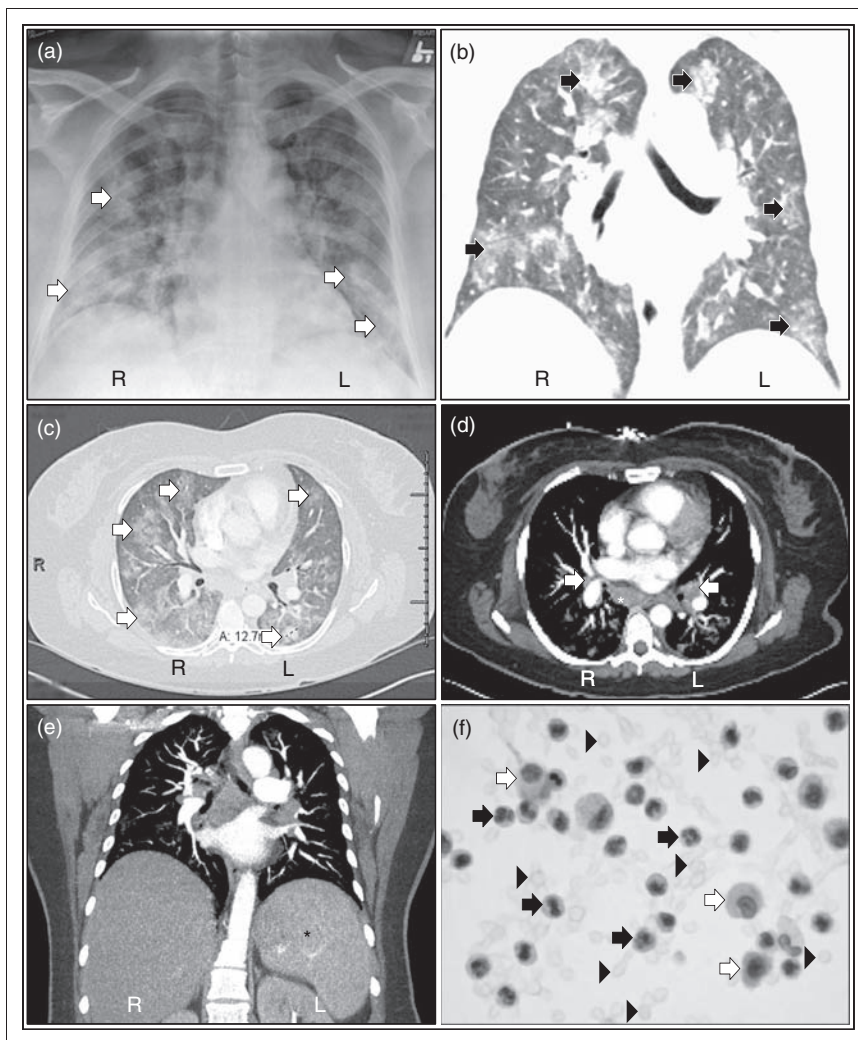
Diffuse alveolar hemorrhage. A chest radiograph demonstrating bilateral patchy airspace opacities (arrows) in the lungs (a). Computed tomographic angiography of the chest and upper abdomen showing bilateral patchy ground-glass opacities (arrows) in the lungs (b, c), enlarged mediastinal (asterisk) and hilar (arrows) lymph nodes (d) as well as enlarged spleen (asterisk) (e). Bronchoalveolar lavage fluid disclosing numerous erythrocytes (arrowheads), polymorphonuclear leukocytes (black arrows), and alveolar macrophages (white arrows) (f).
